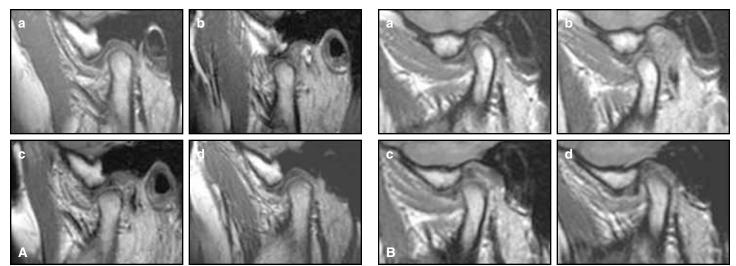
Parasagittal magnetic resonance imaging (MRI) of right (A) and left (B) TMJ regions, showing physiologic disc-condyle relationships before Herbst treatment (a), after placement of Herbst appliance (b), after three months of Herbst treatment (c), and after Herbst removal (d).
